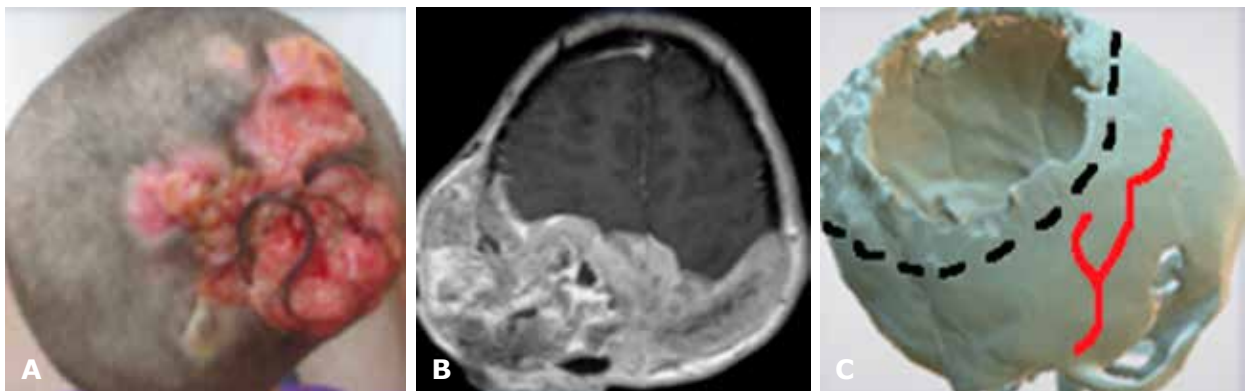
Patient M.: A - appearance of the patient before surgery; B - CT data before surgery; C - 3D modeling data and CS before surgery. Giant defect of dura mater, skull bones and skin
